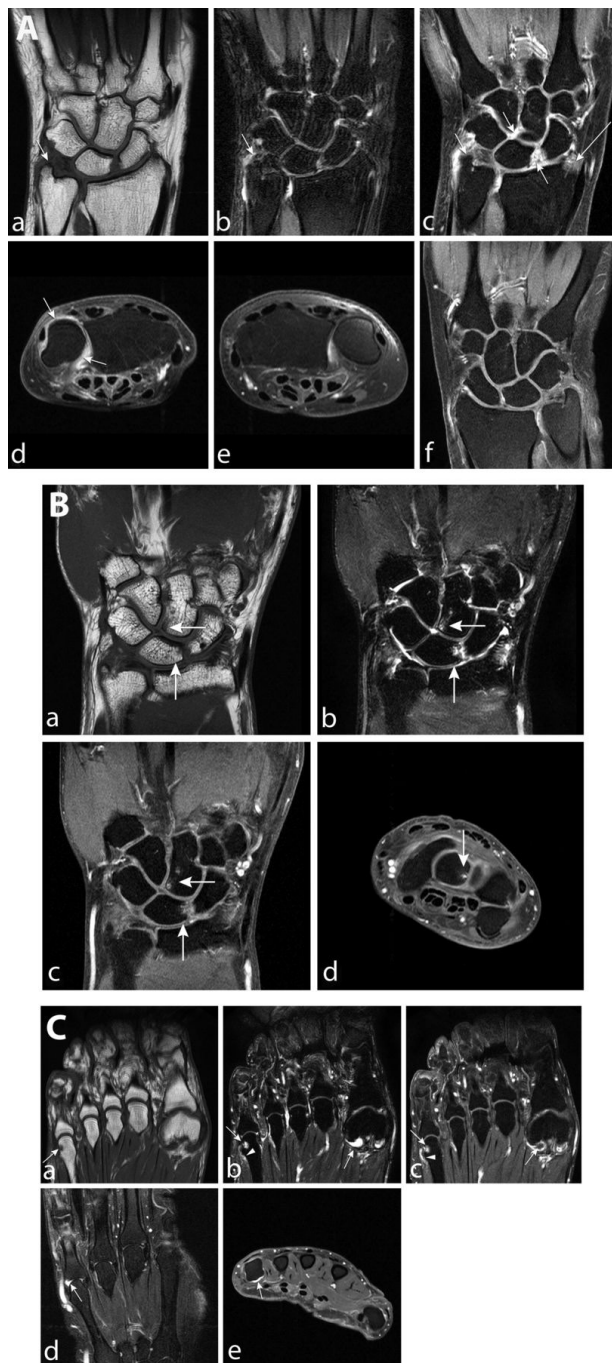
MR images of anticitrullinated peptide antibody positive arthralgia patients without clinically detectable arthritis. (A) MR images of the left hand; the right hand is shown for comparison. Coronal T1 TSE, T2 TSE fatsat and T1 fatsat after gadolinium (A (a–c)). Axial image at the level of the distal radioulnar joint (A (d)). The right hand is shown for comparison: T1 fatsat after gadolinium axial (A(e)) and coronal (A (f)) without enhancement. In the left hand, increased volume of soft tissues is evident around the distal ulna, intermediate of signal intensity on T1 (A (a)), high on T2 (A (b)) (arrow). After gadolinium, abundant enhancement of thickened synovium is evident around the distal ulna and among the carpal joints (arrows A (c), (d)). According to the Rheumatoid Arthritis MRI Scoring (RAMRIS) method, synovitis was scored. Partial volume is seen at the processus styloideus radii (long arrow). (B) MR images of the left wrist. At the proximal end of the hamate and at the lunate, regions of low intensity on T1 (B (a)) and high intensity on T2 (B (b)) and high intensity on T1 after gadolinium (B (c), (d)) are appreciated, which represents bone marrow oedema. Furthermore, no enhancement of the synovium is seen (B (c), (d)). Therefore, no synovitis was scored. (C) MR images of the left foot (C (a–c)) and left hand (C (d), (e)). The head of metatarsal 5 showed a small lesion (arrows), low on T1 (C (a)), high on T2 (C (b)), enhancing after gadolinium (C (c)), which could be an erosion or synovial cyst. Subtle enhancement of synovium is seen laterally (arrowhead). A small amount of fluid with rim enhancement of synovium of metatarsophalangeal 1 (arrow) is present. No bone marrow oedema is appreciated. The left hand shows a subtle amount of high signal intensity in metacarpophalangeal 5, enhancing after gadolinium (C (d), (e)), consistent with subtle synovitis.
